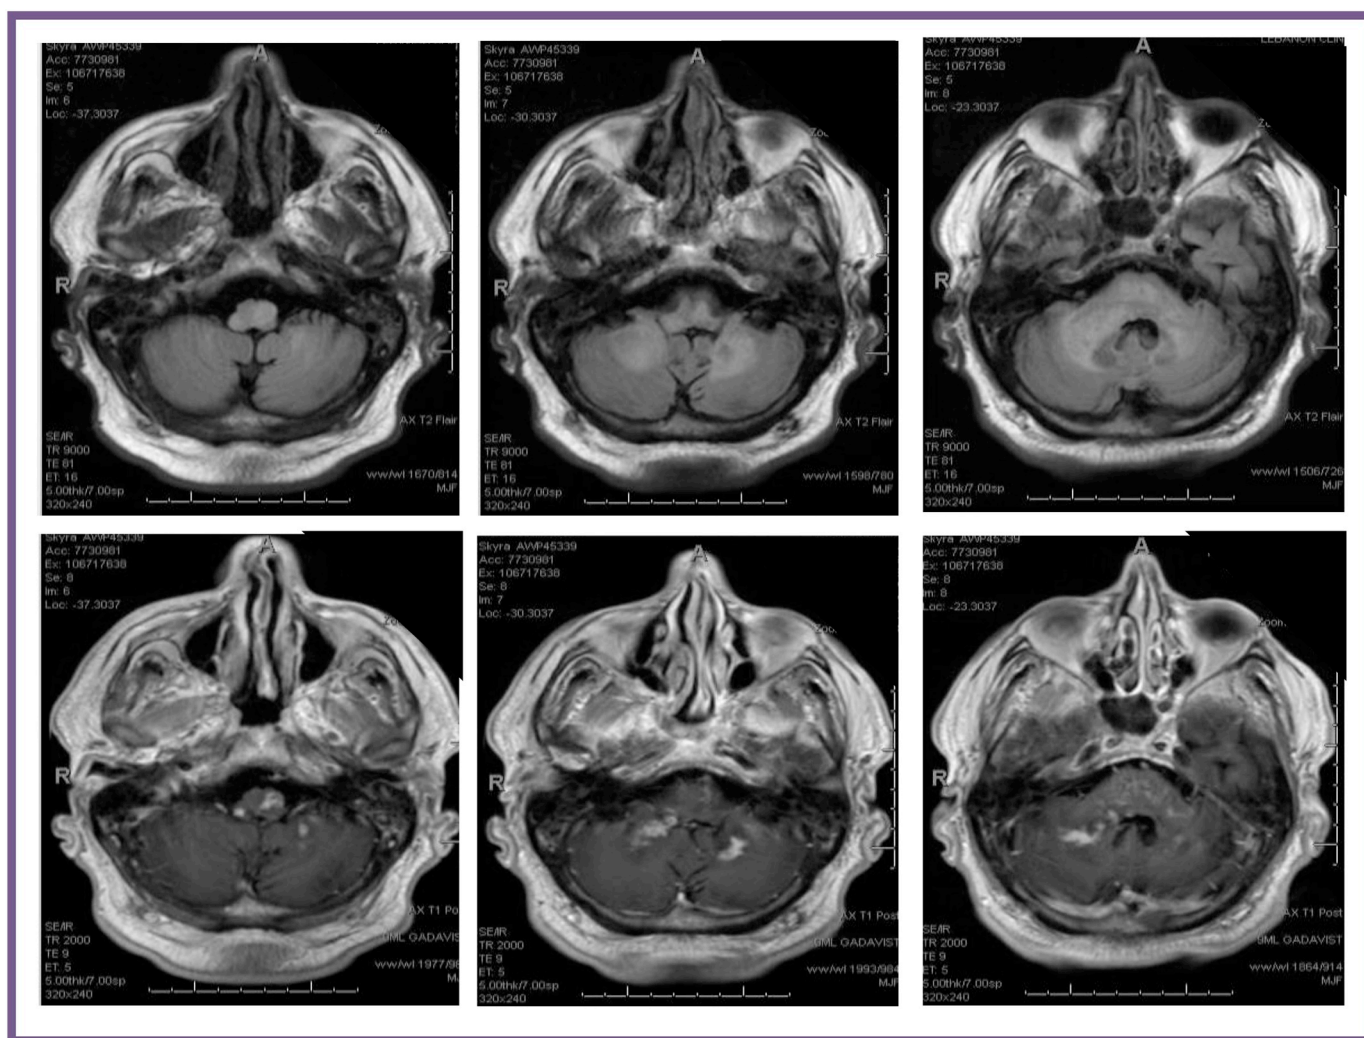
Patient 2 axial FLARE and T1 post contrast MRI slices in April 2017<sup>a</sup>.
